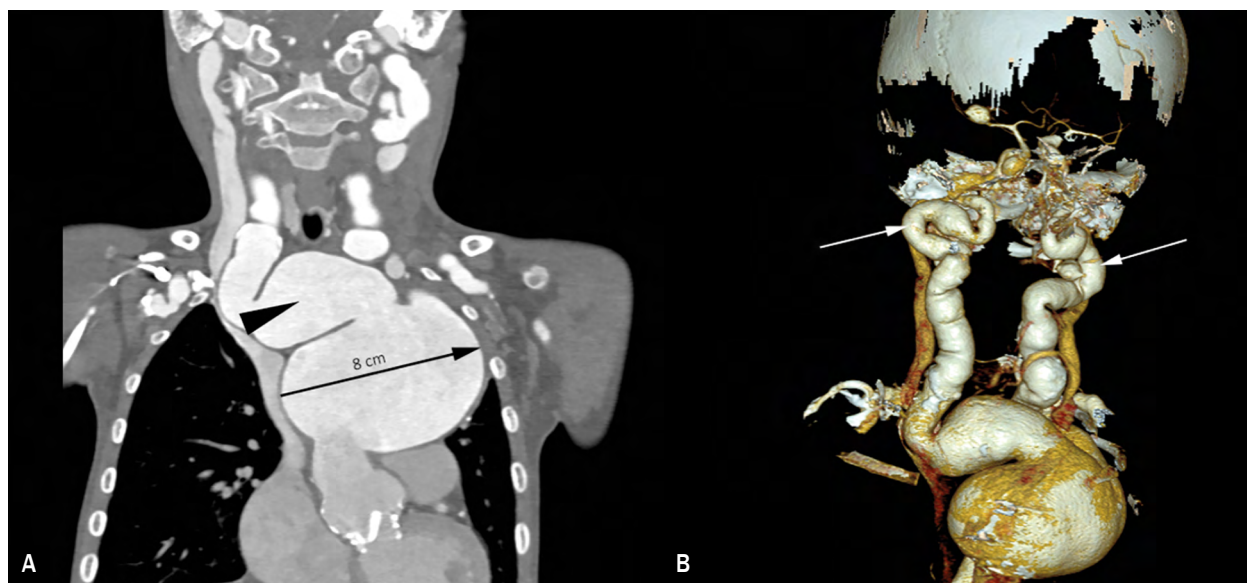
Multislice CT angiography of an 8-year-old boy with radiological diagnosis of Loey-Dietz syndrome; A. Coronal CT angiogram shows an 8 cm aortic arch aneurysm (arrow) and dilated brachiocephalic trunk with a maximal diameter of 3.25 cm (arrowhead); B. 3D volume rendering image reveals markedly tortuous left and right common carotid arteries (arrows). Additional CT finding includes an aneurysm of the right middle cerebral artery (arrowhead); CT – computed tomography
